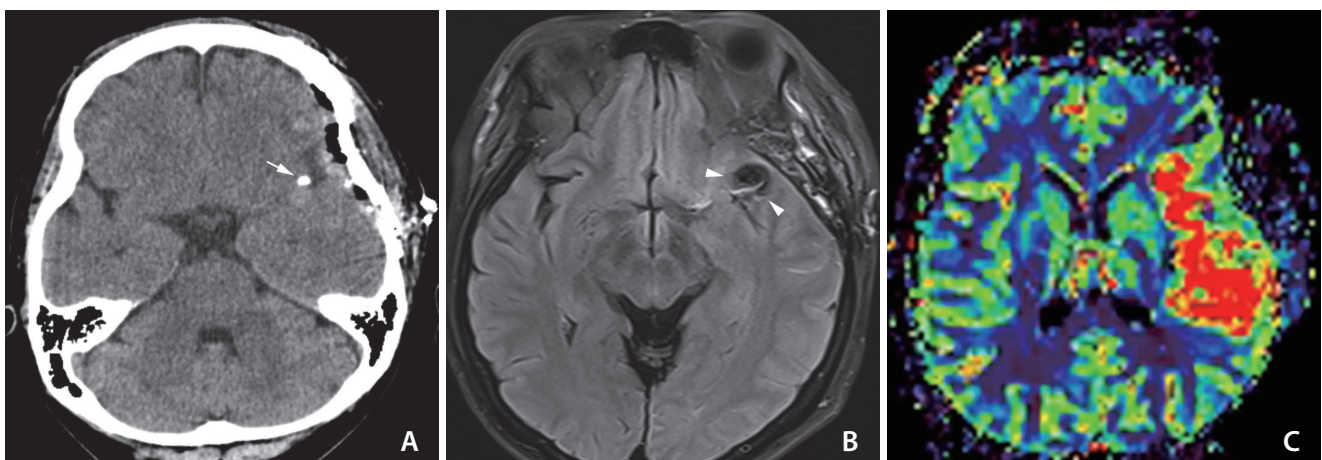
Initial neuroimages of the patient at the ischemic symptom onset. (A) Computed tomography scan demonstrates the successful clipping of the left middle cerebral artery (MCA) bifurcation aneurysm without significant hyperacute stroke. Very bright, high signal intensity at the left Sylvian fissure regarding the metal clip artifact was observed (white arrow). (B) Some suspicious hyperintense vessel signs on the fluid attenuated inversion recovery image suggested that ischemic changes (white arrowheads) are noted in the left Sylvian region and temporal lobe. (C) Magnetic resonance perfusion showing marked increased mean transit time in the left MCA distribution.
